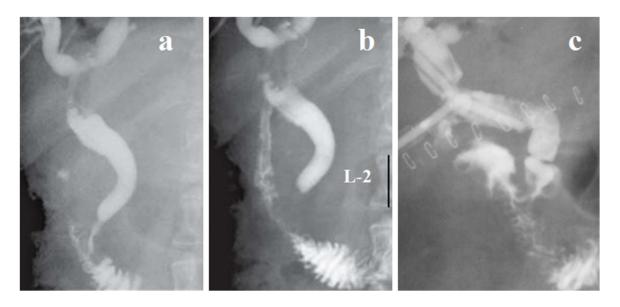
(a-b) Endoscopic retrograde cholangiopancreatography (ERCP) in a patient with obstructive jaundice. It is known that the true height of L-1 is 2.2 cm. However, it turned out to be impossible to accurately determine the height L-1 on the radiograph. We measured the L-2 height, assuming it to be 2.3 cm. The length of the non-contrasting gap between the common duct and the duodenum is approximately 1.3 cm. This is the contracted SO. (c) A significant expansion of the common bile duct is combined with a shortening of SO. Its upper part looks like an ampulla.
